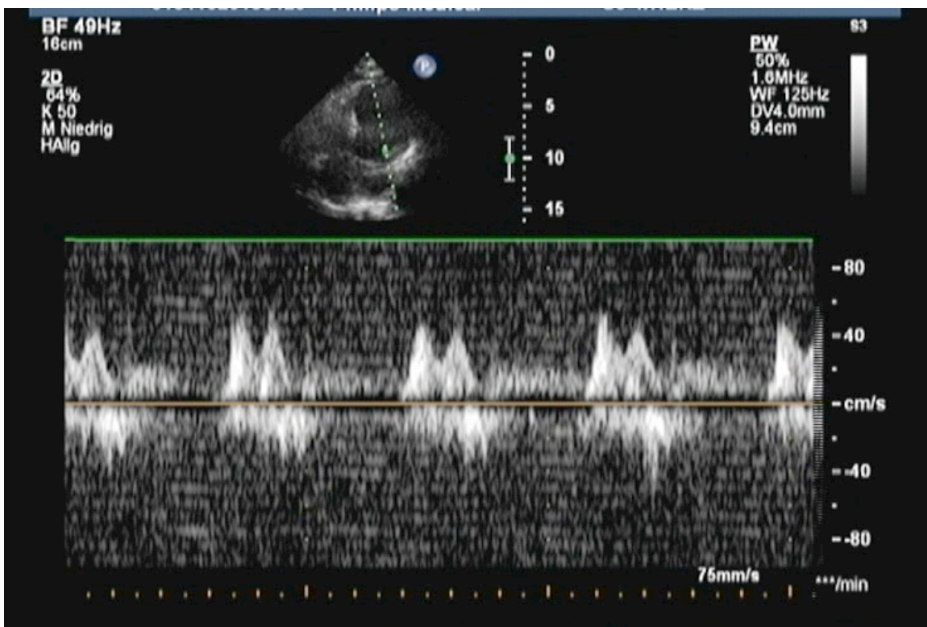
Doppler analysis feasibility: a) filling pattern of left ventricle, b) pulmonary pressure assessment c) RV outflow tract Doppler assessment (for RV output calculation)
